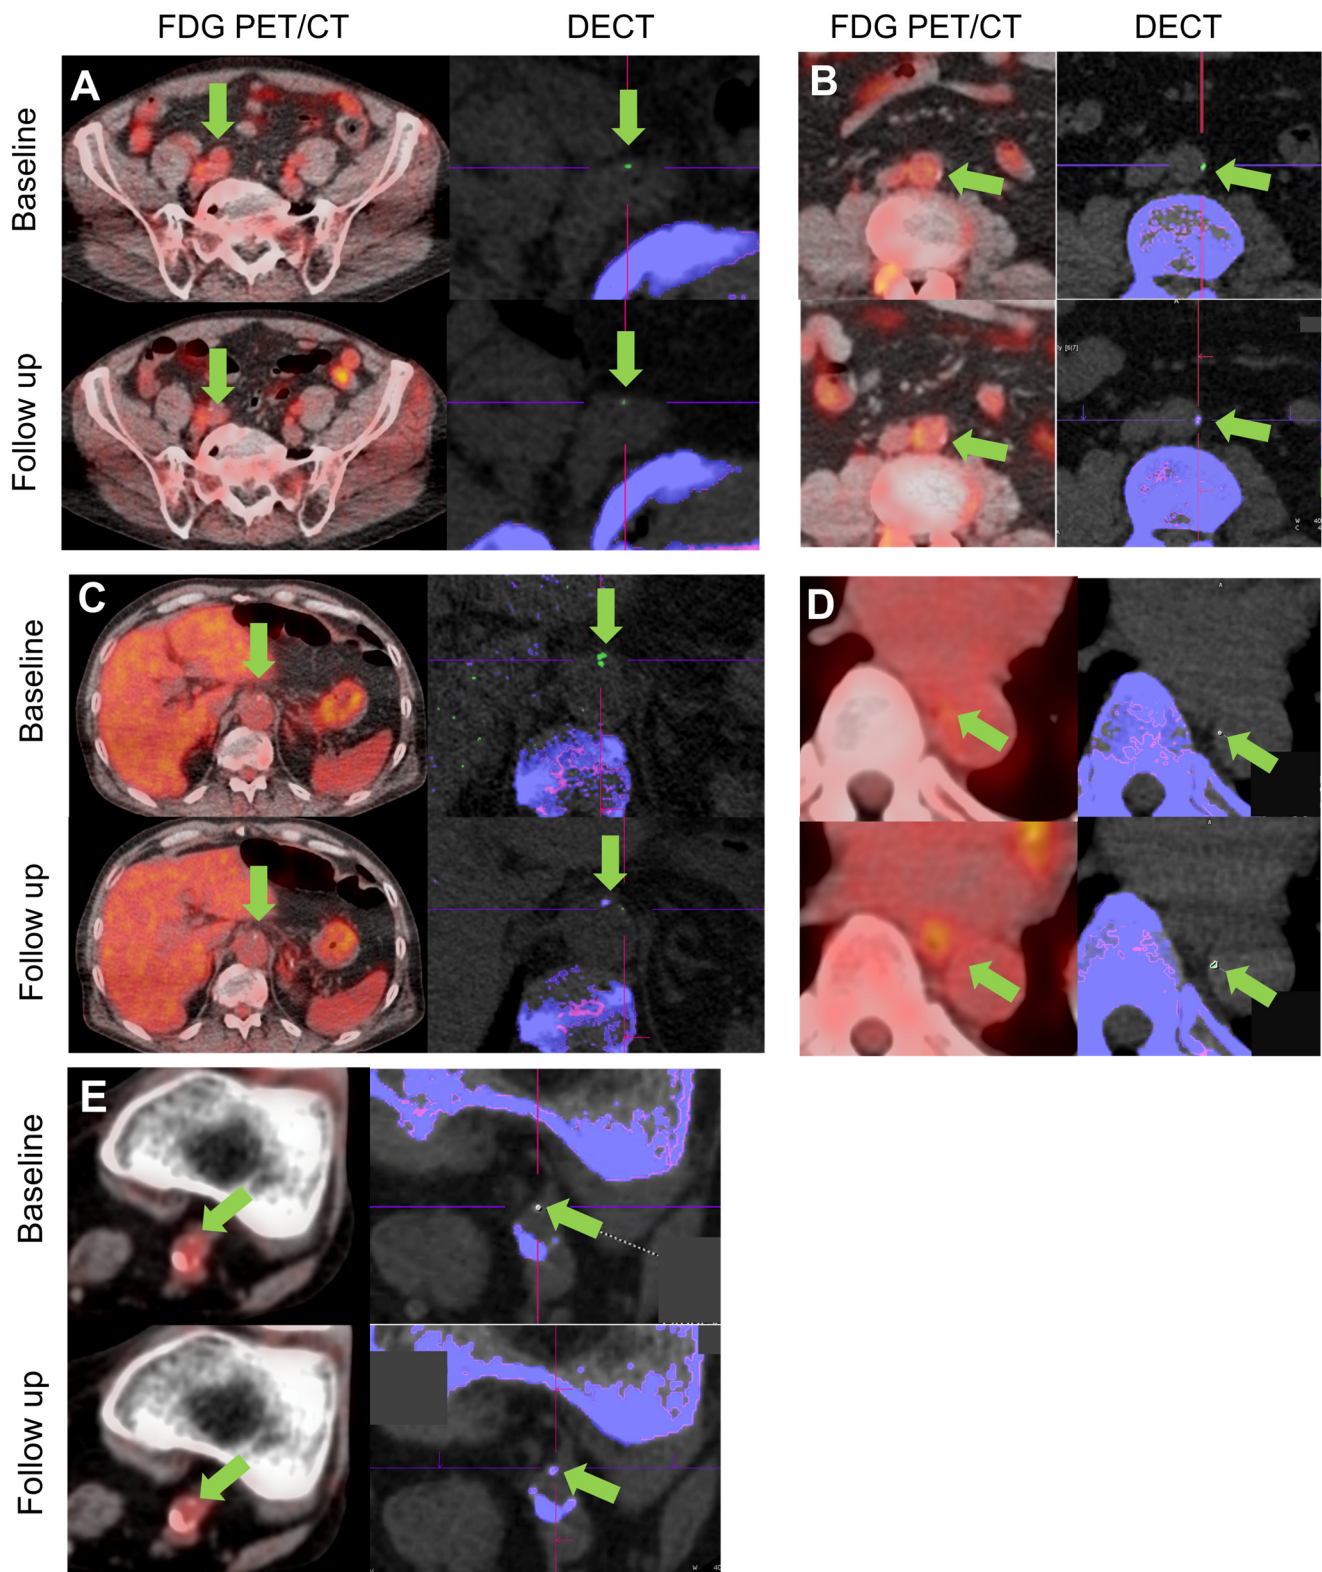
Representative PET/CT (left) and DECT images (right) from axial locations in five vessel levels in four patients. (A) ^{18}F -FDG uptake (orange overlay) shows inflammation in the right iliac artery (green arrow). On DECT, MSU-coded deposits (green) are shown in the corresponding vessel
